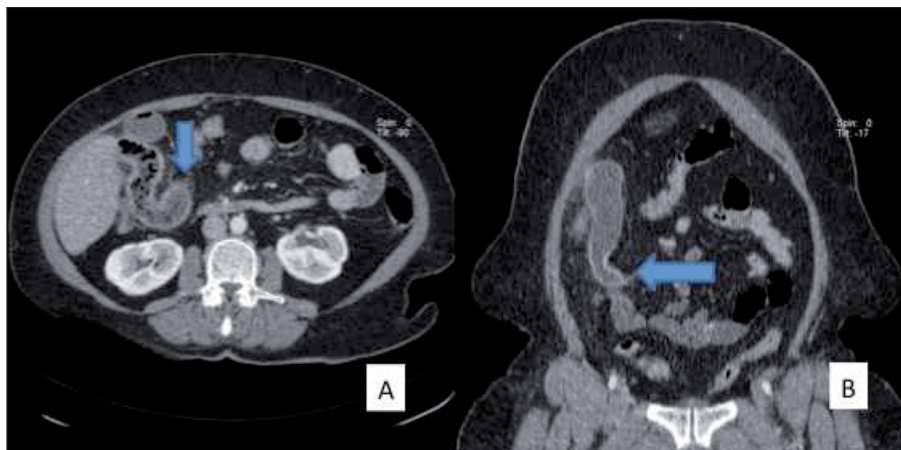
Axial and coronal computed tomography images of 2 different patients with intravenous contrast material demonstrating 'beak sign' at the point of obstruction (arrows) and dilated bowel loops proximal to the point.
